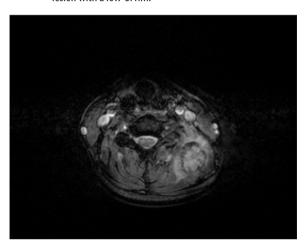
Axial, T2-weighted FS image shows intermediate- to high-SI of the lesion with a low-SI rim.
